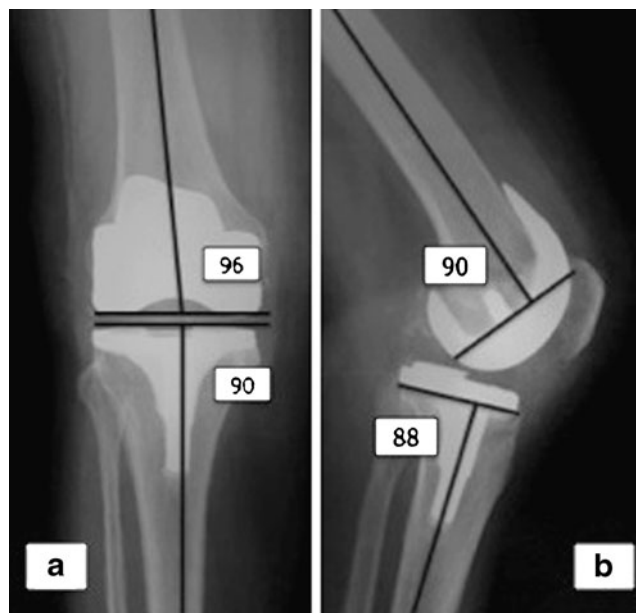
Postoperative a anteroposterior and b lateral radiographs of a right knee 2 years after MIS-TKR. Implants position in relation to anatomical axis has been shown in coronal and sagittal planes. The presented values are in normal limits
